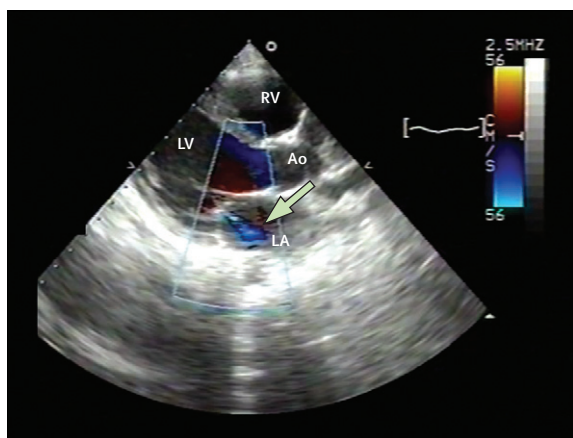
Transthoracic echocardiogram of patient with subclinical rheumatic heart disease
